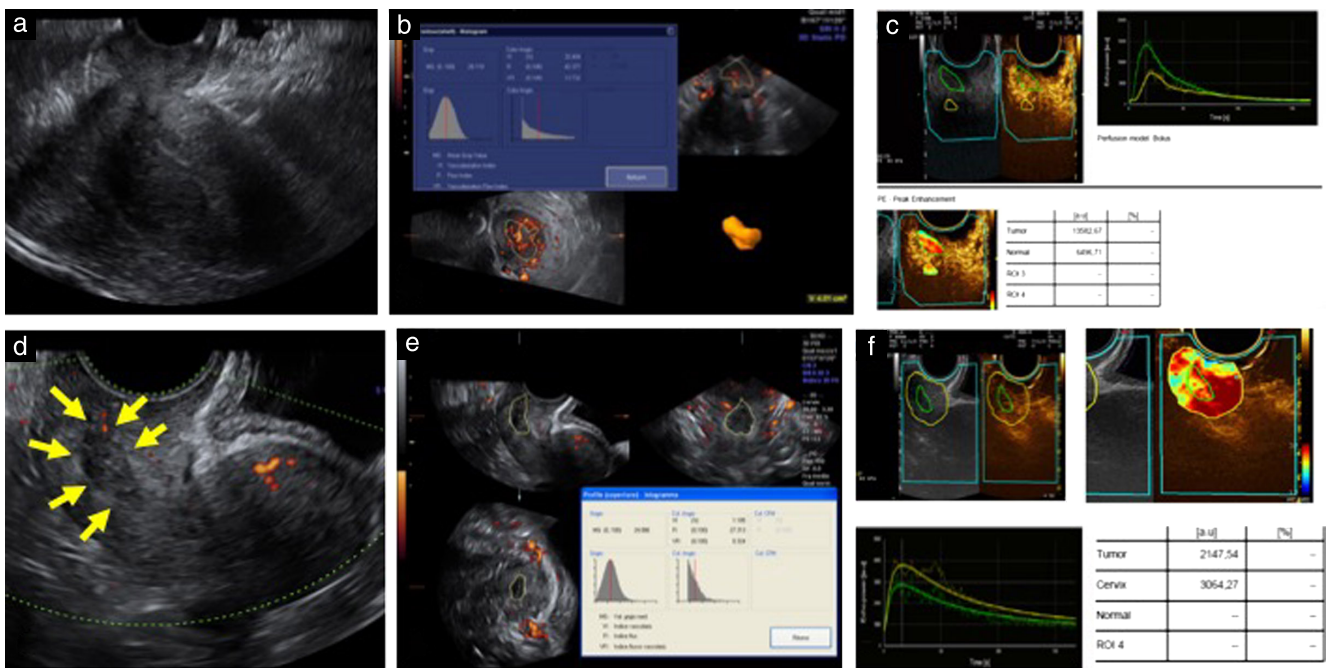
Images from two cases with visible lesion on ultrasound, one having pathological partial response (a–c) and the other pathological complete response (d–f), showing findings on two-dimensional power Doppler (a,d), three-dimensional power Doppler (b,e) and contrast-enhanced examination (c,f).
